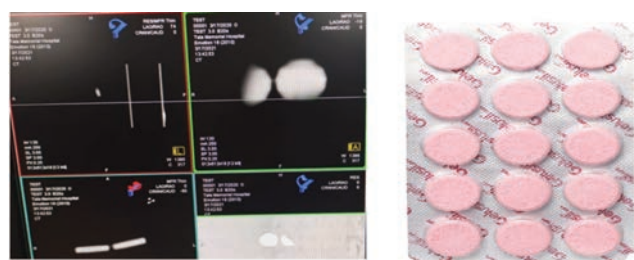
Computed Tomography (CT) image of antacid tablets.
